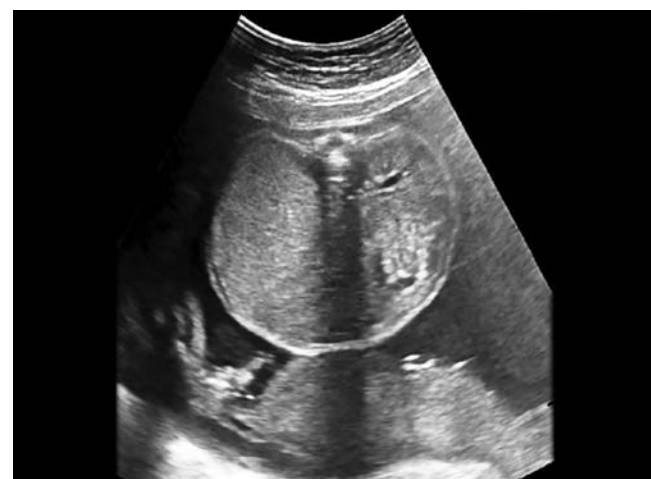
Coronal ultrasound image with echogenic lungs and dilatation of the trachea distal to the obstruction
